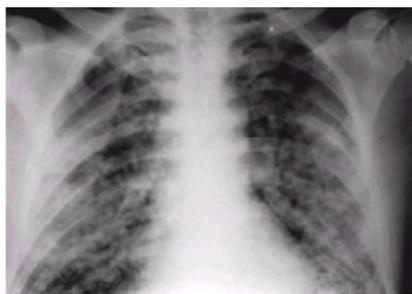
Posteroanterior radiograph of a 55-year-old man with acute phosgene poisoning. Extensive alveolar shadowing is present, with a normal-sized heart and no evidence of diversion of blood to veins of the upper lobes.
